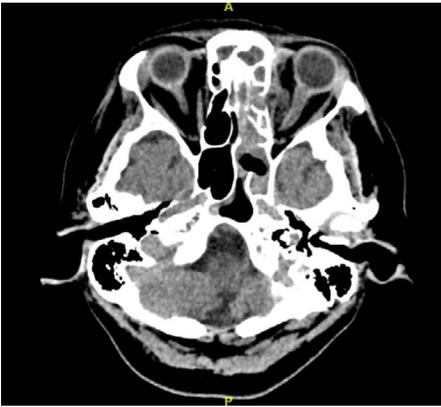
Computed tomography of the orbit and paranasal sinuses showing mixed density lesion in left nasal cavity and ethmoid sinus, with extension to lateral extraconal space of left orbit. Left optic nerve was displaced and appear thickened.
